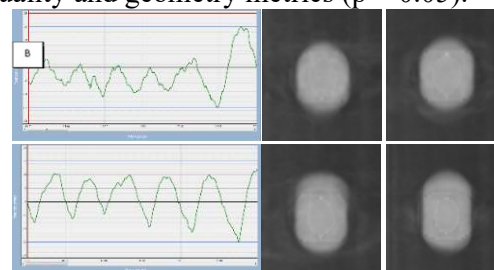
The 4D-CBCT images depict patient patterns in rows A and B, with the default protocol in the middle and the modified protocol on the right.
